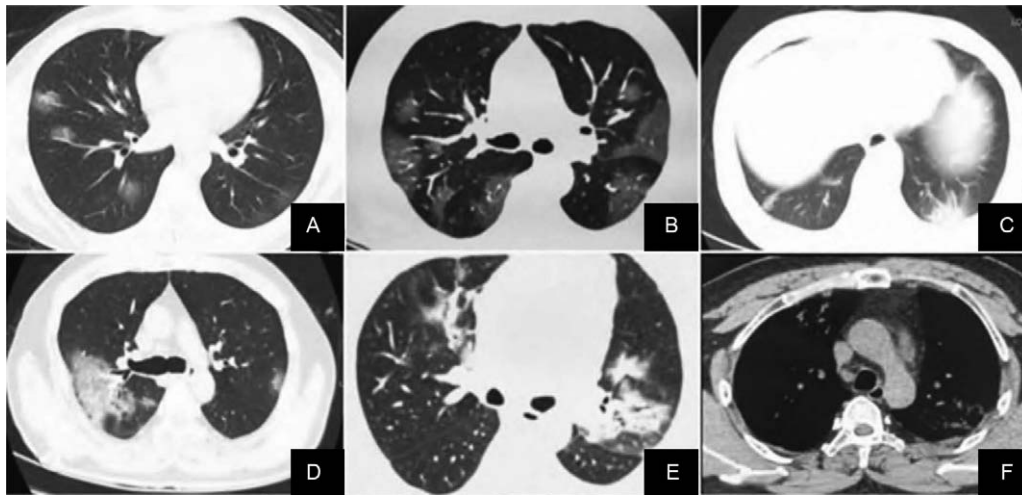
Chest CT images of novel coronavirus 19 pneumonia patients undergoing initial examination. A. Ground glass shadows can be seen in both lungs, and blood vessels are congested and thickened. B. CT showed subpleural ground glass shadows in both lungs with vascular congestion and thickening. C. Hypopleura consolidation with bronchiectasis in the left lower lung. D. The right lung shows large ground glass shadows, thickened interlobular septa, and a small amount of pleural effusion. E. Bilateral lungs show ground glass shadow, consolidation shadow, air bronchogram, and fibrotic lesions. F. The same patient as E, showing enlarged mediastinal lymph nodes. CT=computed tomography.
